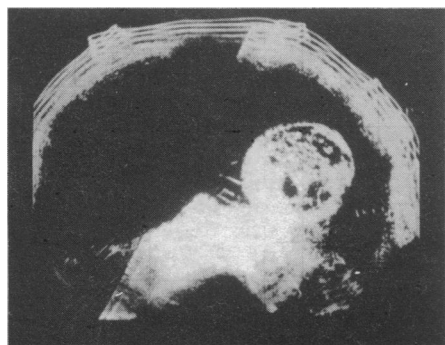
Sonogram. Transverse B-scan 2 cm below umbilicus.
